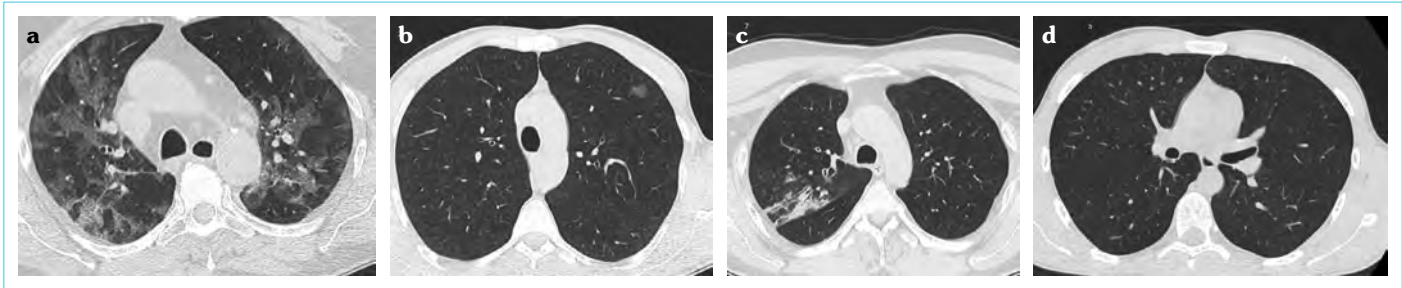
(a) Type 1 findings in thoracic computed tomography according to RSNA classification. (b) Type 2 findings in thoracic computed tomography according to RSNA classification. (c) Type 3 findings in thoracic computed tomography according to RSNA classification. (d) Type 4 findings in thoracic computed tomography according to RSNA classification
